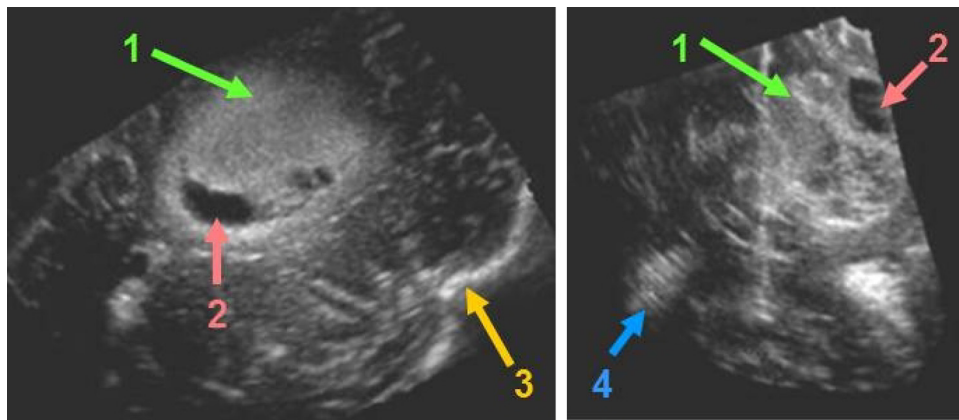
Ultrasound images of gliomas. Left: grade II glioma (patient #11). Right: grade IV glioma (patient #4). The colored numbers correspond to the following: (1) tumor, (2) cystic component, (3) bone, and (4) choroid plexus.
